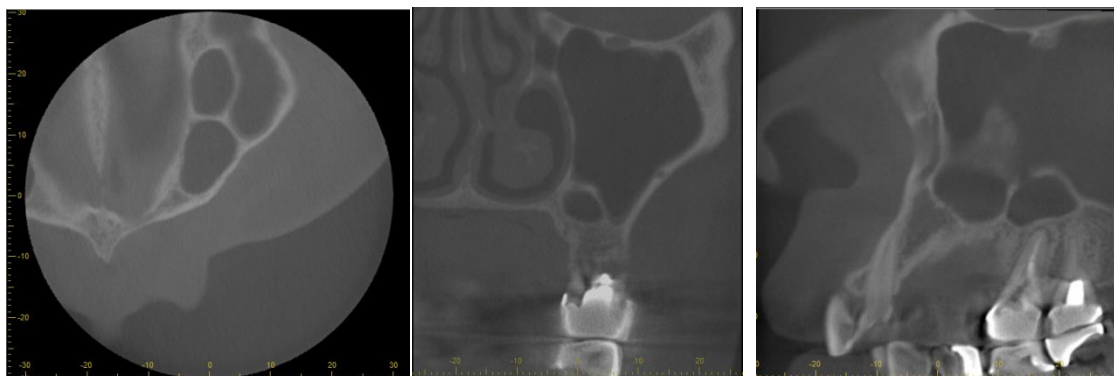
Left complex septa from CBCT image (case 3)
